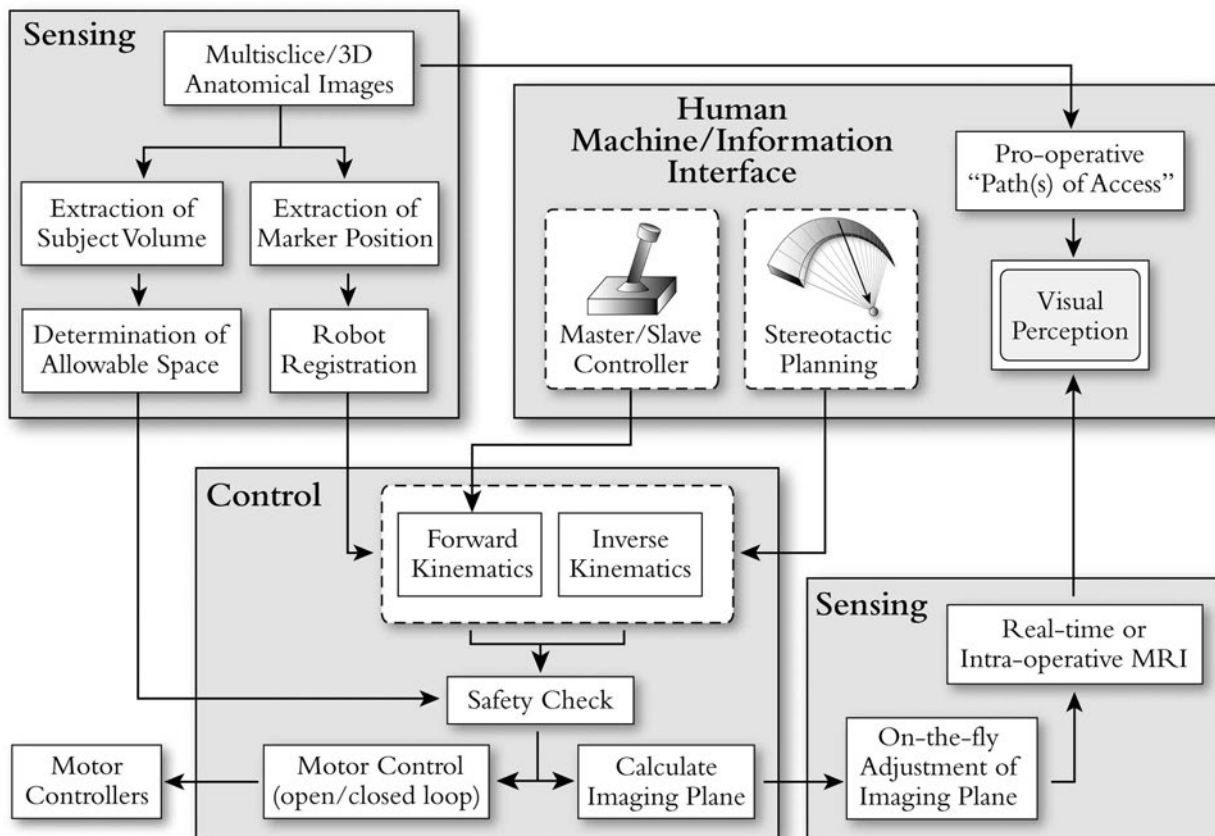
The processes and flow of information for an example of MR image-based interventional robot control software [as implemented with the robotic system in Tsekos et al. (2005)]. The three interrelated elements of sensing, control, and perception are delineated with the boxes shaded in gray; unlike Figure 5–2, this system does not include modeling or haptics. The robot is registered relative to the coordinate system of the MR scanner. From multislice anatomical MR images, the software determines the “Allowable Space” inside the MR scanner for use by the Safety Check routine, to prevent collisions of the robot with the subject. The registration information is used also by both the forward and inverse kinematics (dotted line box). The operator uses either stereotactic or “freehand” master/slave control. In the former case, the inverse kinematics equations are solved to determine the appropriate set of DOF values, as well as their compliance with the safety routine. In the latter, the forward kinematics equations yield the coordinates of the requested final position; this kinematic configuration of the robot is then tested for compliance with the safety routine, and it is executed only if the requested motion is within the allowable space. With the freehand control method, the operator manually adjusts the robot.
